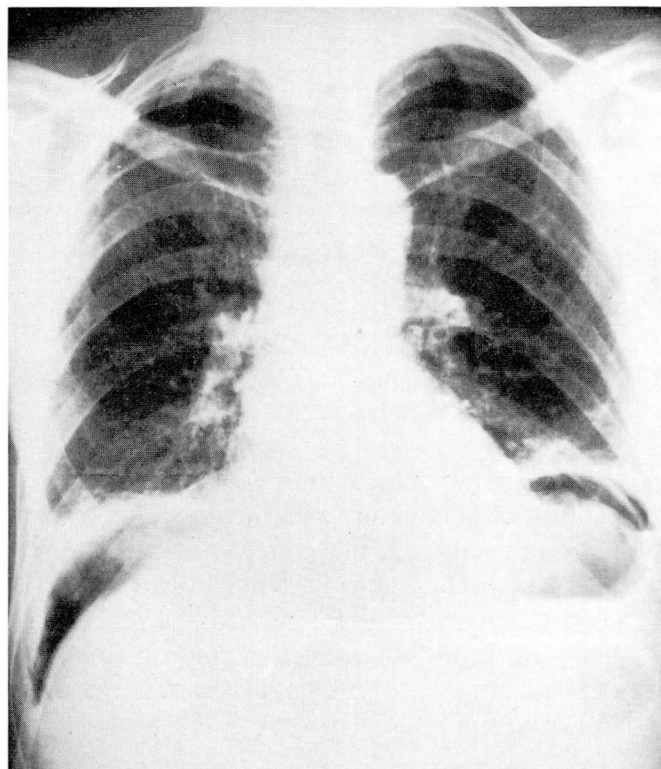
Upright chest X-ray demonstrating free air under the diaphragm in a patient with a perforated duodenal ulcer.
